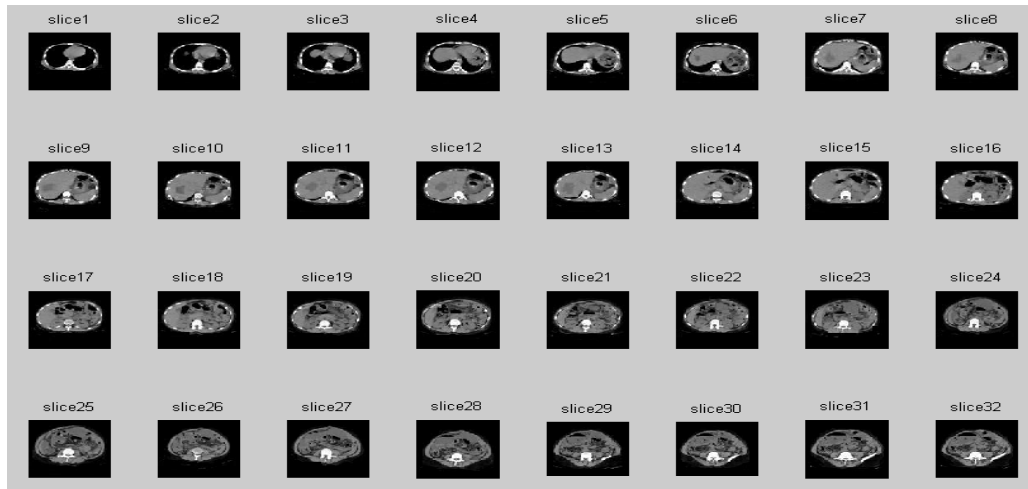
Set of Liver Slices obtained by CT Scan
